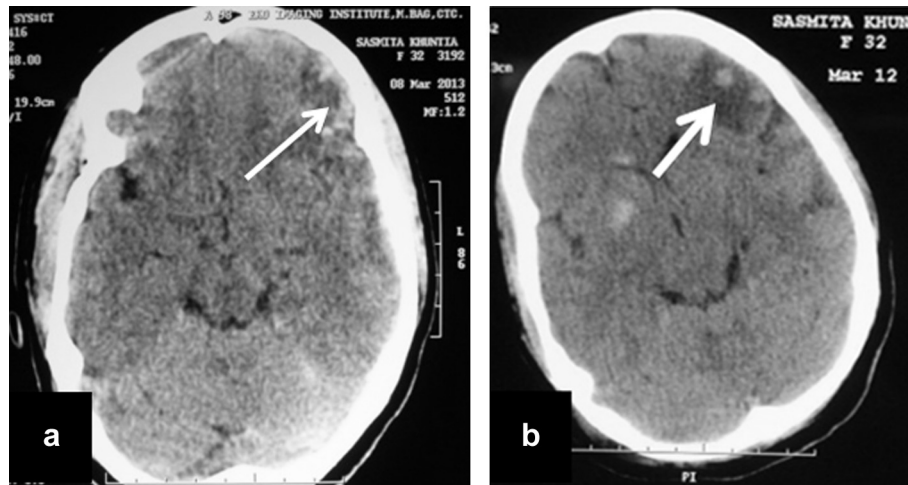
(a) CT scan of brain showing hypodense lesion in the Lt. Frontal region suggestive of hemorrhagic contusion. (b) Resolving contusion on repeat CT scan of brain 4 days after conservative management.
